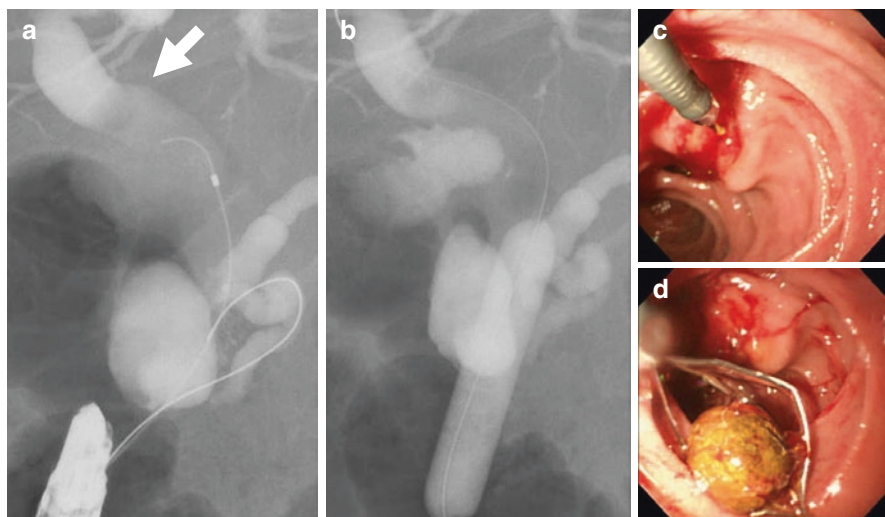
EPLBD in patient with Billroth II gastrectomy. (a) Cholangiogram showed a bile duct stone (arrow). (b) X-ray showed large balloon expanded. (c) After EPLBD, a mechanical lithotripter was used for stone extraction. (d) Large bile duct stone removed without crush
